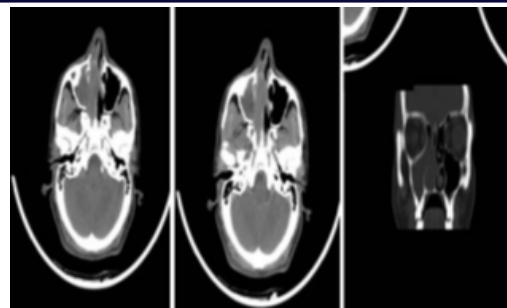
Right inverted papilloma: Axial and Coronal CT shows lobulated soft tissue attenuating mass in right nasal cavity extending into maxillary sinus with adjacent bony remodeling.
